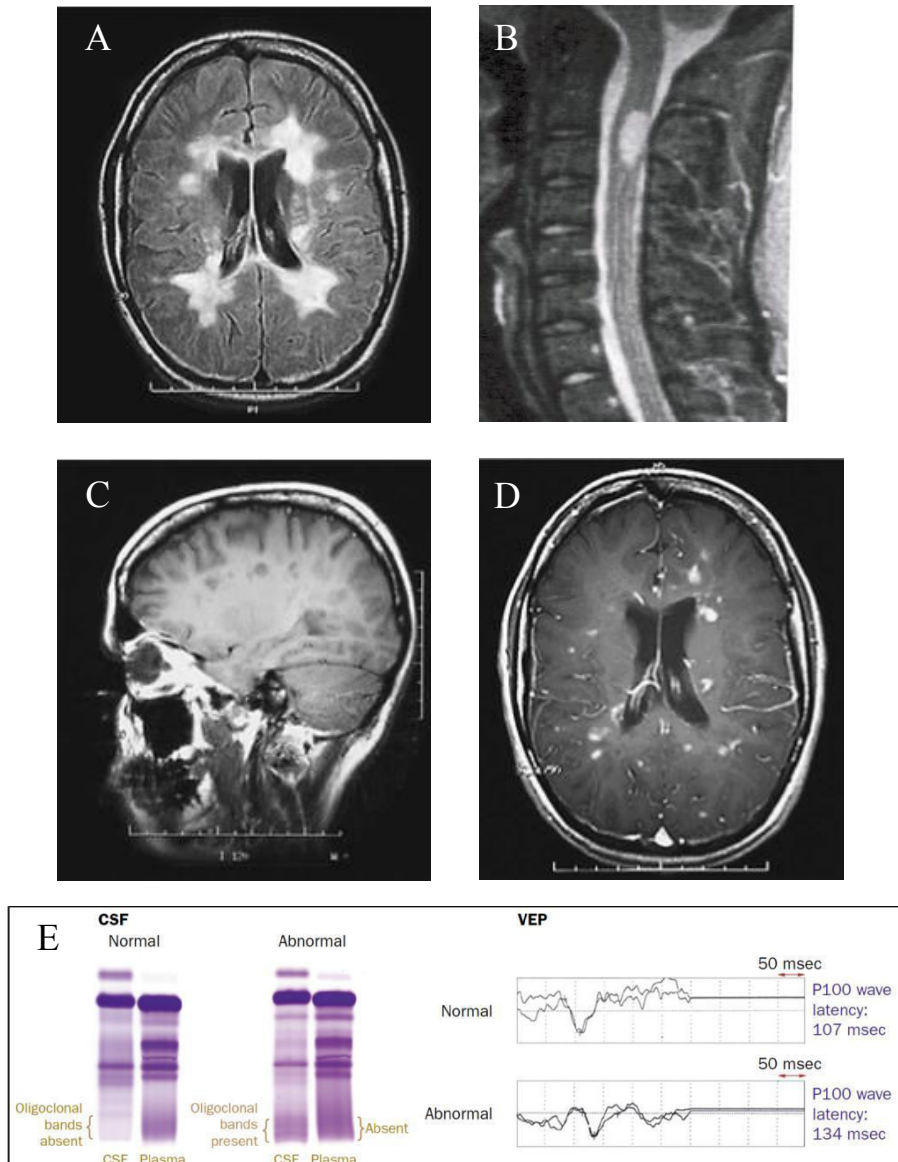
Clinical investigations for MS diagnosis.* (A) An axial FLAIR T₂-weighted MRI scan of MS brain shows multiple ovoid hyperintense lesions in the periventricular WM. (B) A cervical spinal cord lesion. (C) A parasagittal T₁-weighted MRI scan shows multiple regions in which the signal is diminished (referred to as “black holes” corresponding to chronic lesions) in the periventricular WM and corpus callosum. (D) After Gd administration, many of the lesions demonstrate ring or peripheral enhancement, indicating the breakdown of the BBB. (E) CSF protein electrophoresis highlights oligoclonal IgG bands in more than 90% of MS cases. Latency of evoked visual potentials (VEP) is typically delayed in MS patients, reflecting the specific effect of demyelination on saltatory conduction. Adapted from Noseworthy et al. (2000). *NEJM*, 343(13):938-52; Compston & Coles (2002). *Lancet*, 359(9313):1221-31.
